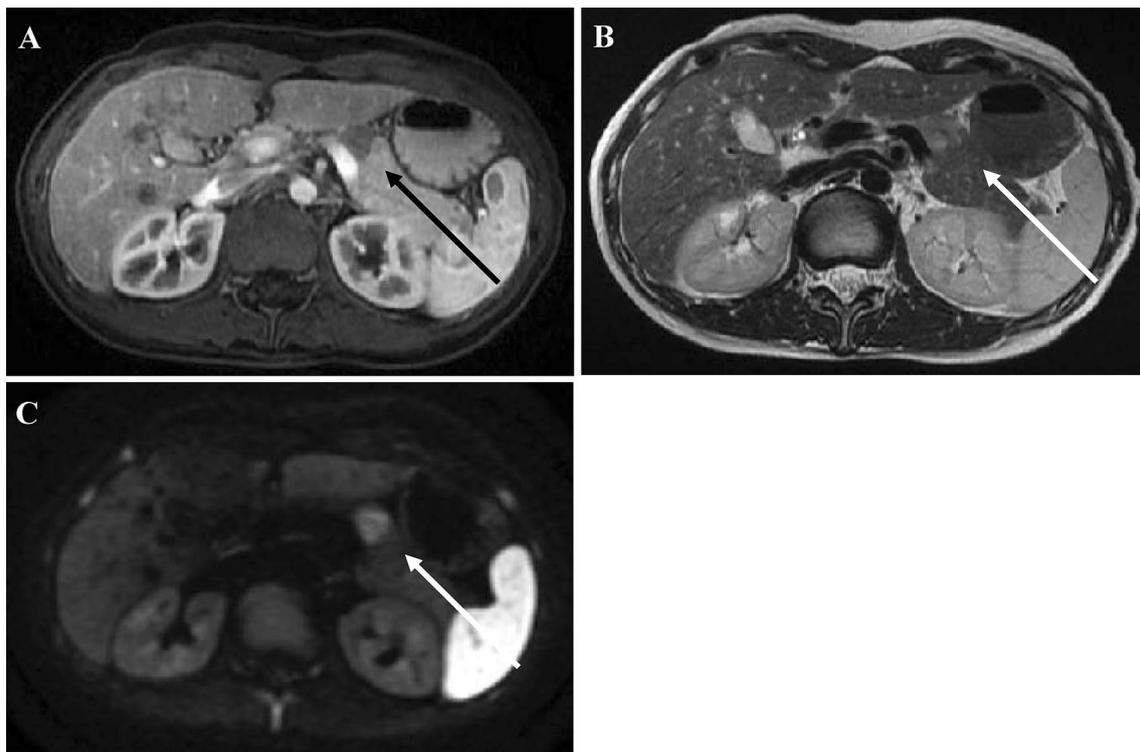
Magnetic resonance imaging. a The tumor shows a well-defined, hypointense mass on T1-weighted image (T1WI) in the pancreatic body without pancreatic duct dilatation (black arrow). b
